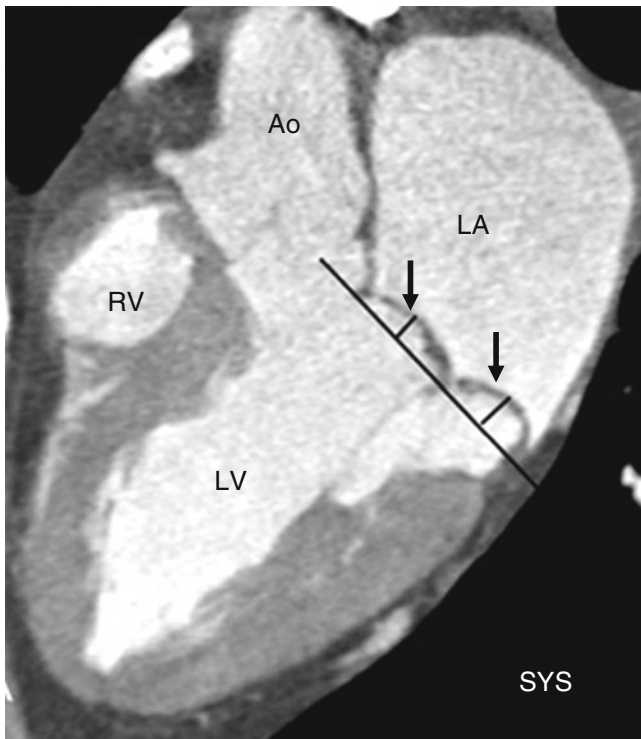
Mitral valve prolapse. This three-chamber computed tomogram demonstrates billowing (bowing of leaflet body) of both mitral valve leaflets (*arrows*) during systole. The leaflets are also thickened. The extent of billowing of the leaflet bodies below the mitral annulus plane is shown by the black lines. *RA* right atrium, *RV* right ventricle, *LA* left atrium, *LV* left ventricle (Reproduced from Feuchtner et al. [20]. With kind permission of Radiological Society of North America, Oak Brook IL)
